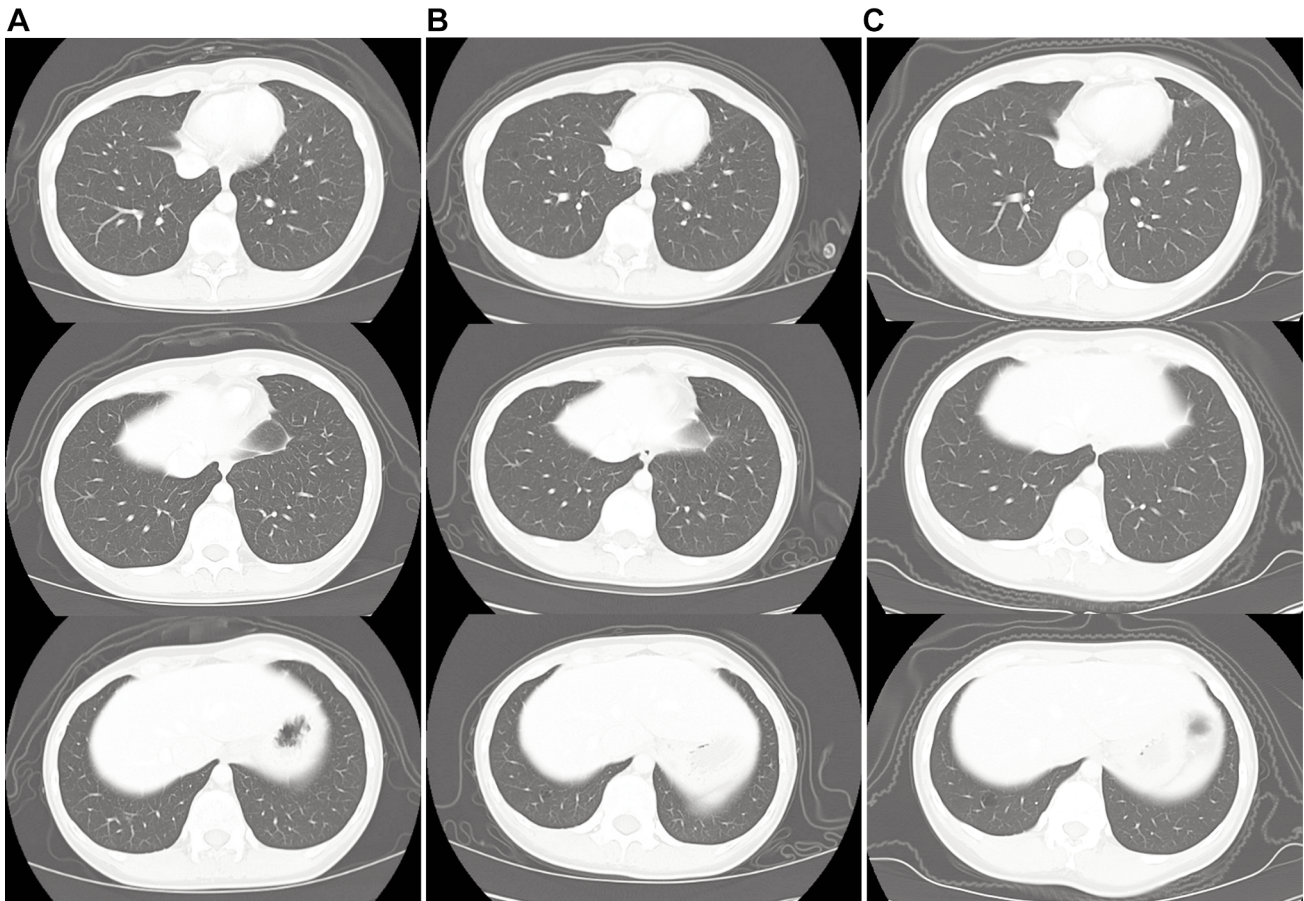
Computed tomography images after starting nivolumab treatment. A) Image taken at 5 months. B) Image taken at 9 months. C) Image taken at 39 months (13 months after stopping nivolumab treatment).
